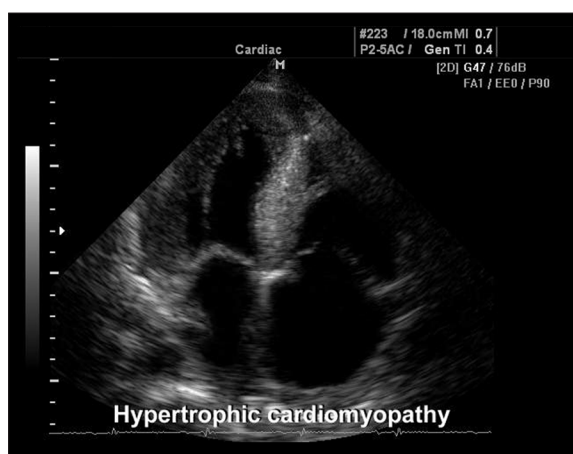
Echocardiography in a 68-year-old male with HCM.
